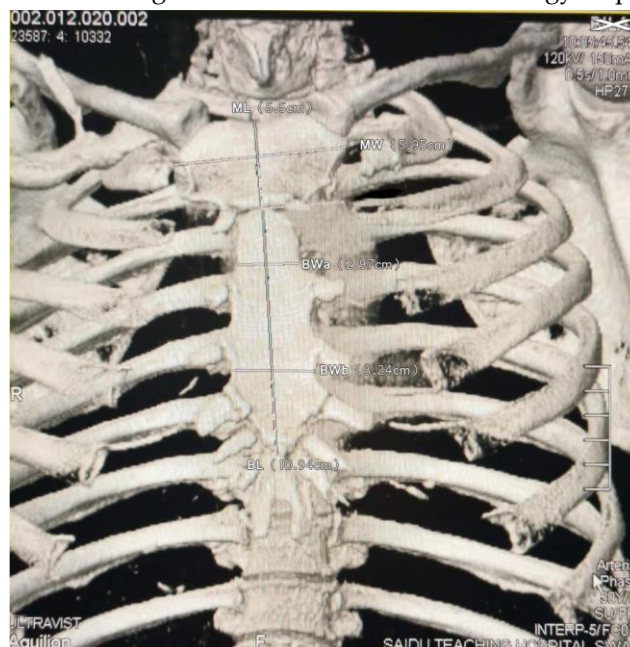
Measurements of the sternal wall dimensions of male on computed tomography
